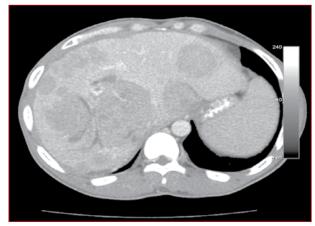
Computed tomography imaging of the liver, showing multiple lesions
